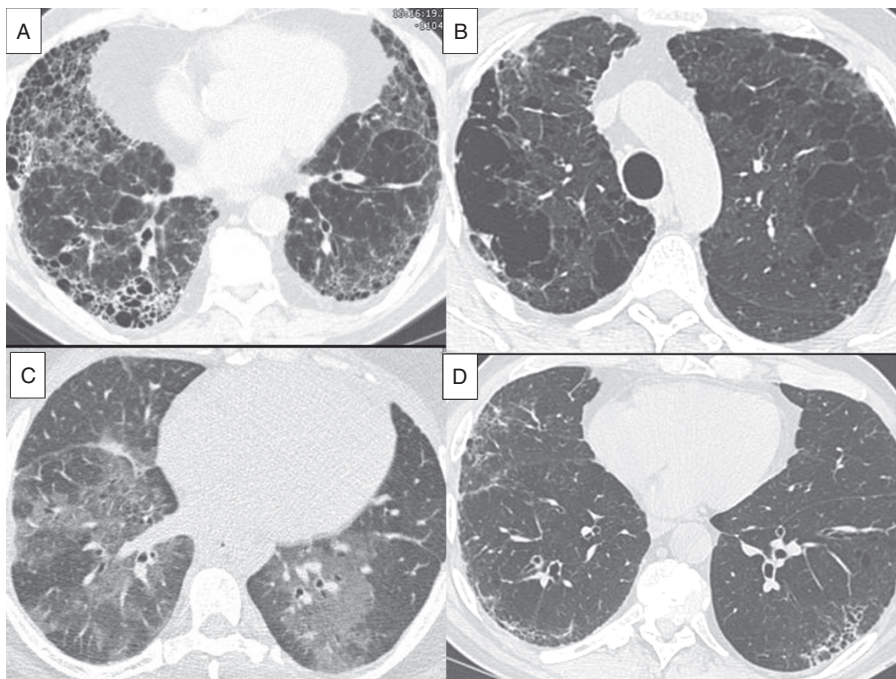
Representative high-resolution computed tomography showing typical features of the 3 major patterns of PF associated with AAV. Predominantly basal, subpleural reticular pattern with macrocystic honeycombing lesions in usual interstitial pneumonia (A). Centrilobular and paraseptal emphysema predominating in the upper lobes (B). Ground-glass opacities in a patchy distribution in nonspecific interstitial pneumonia (C), and reticular subpleural changes in the lower lobes, associated with few microcystic lesions suggesting honeycombing (D) in combined pulmonary fibrosis and emphysema syndrome.
